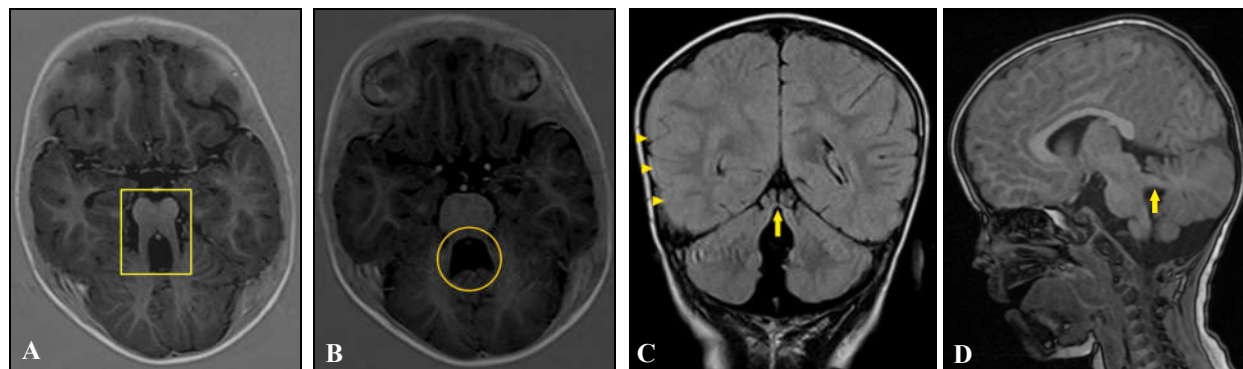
T1W (A, B, D) and FLAIR (C) images showing molar tooth configuration of the brainstem (square), bat-wing appearance of fourth ventricle (circle), thickened cortical gyri (arrowheads), absent inferior cerebellar vermis, and elongated, horizontally placed superior cerebral peduncles (arrows). Overall appearances are consistent with a diagnosis of Joubert syndrome.
